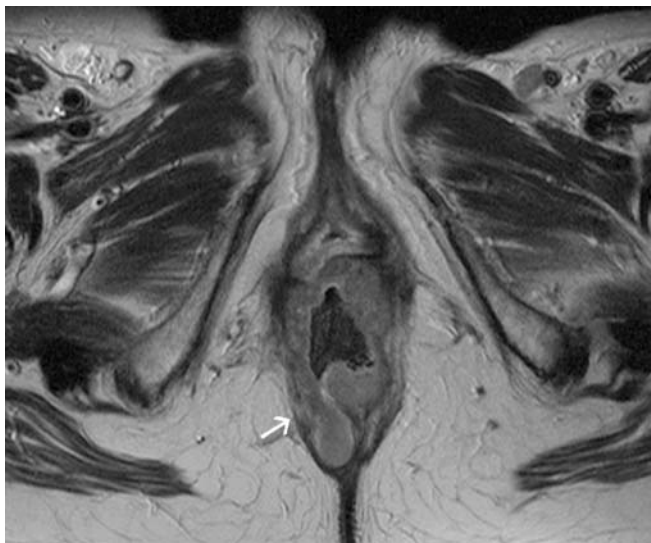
Paraxial T2-weighted FSE (TSE) sequence of a low T4 rectal cancer with infiltration of the levator ani muscle (arrow)
